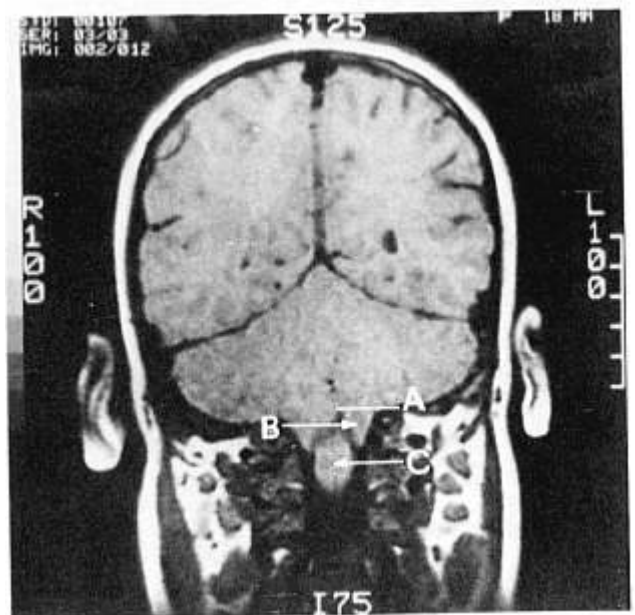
Magnetic resonance image of the mastoid coronal section in this child with Arnold-Chiari malformation type I. A = foramen magnum level; B = cerebellar herniation; C = spinal cord.
